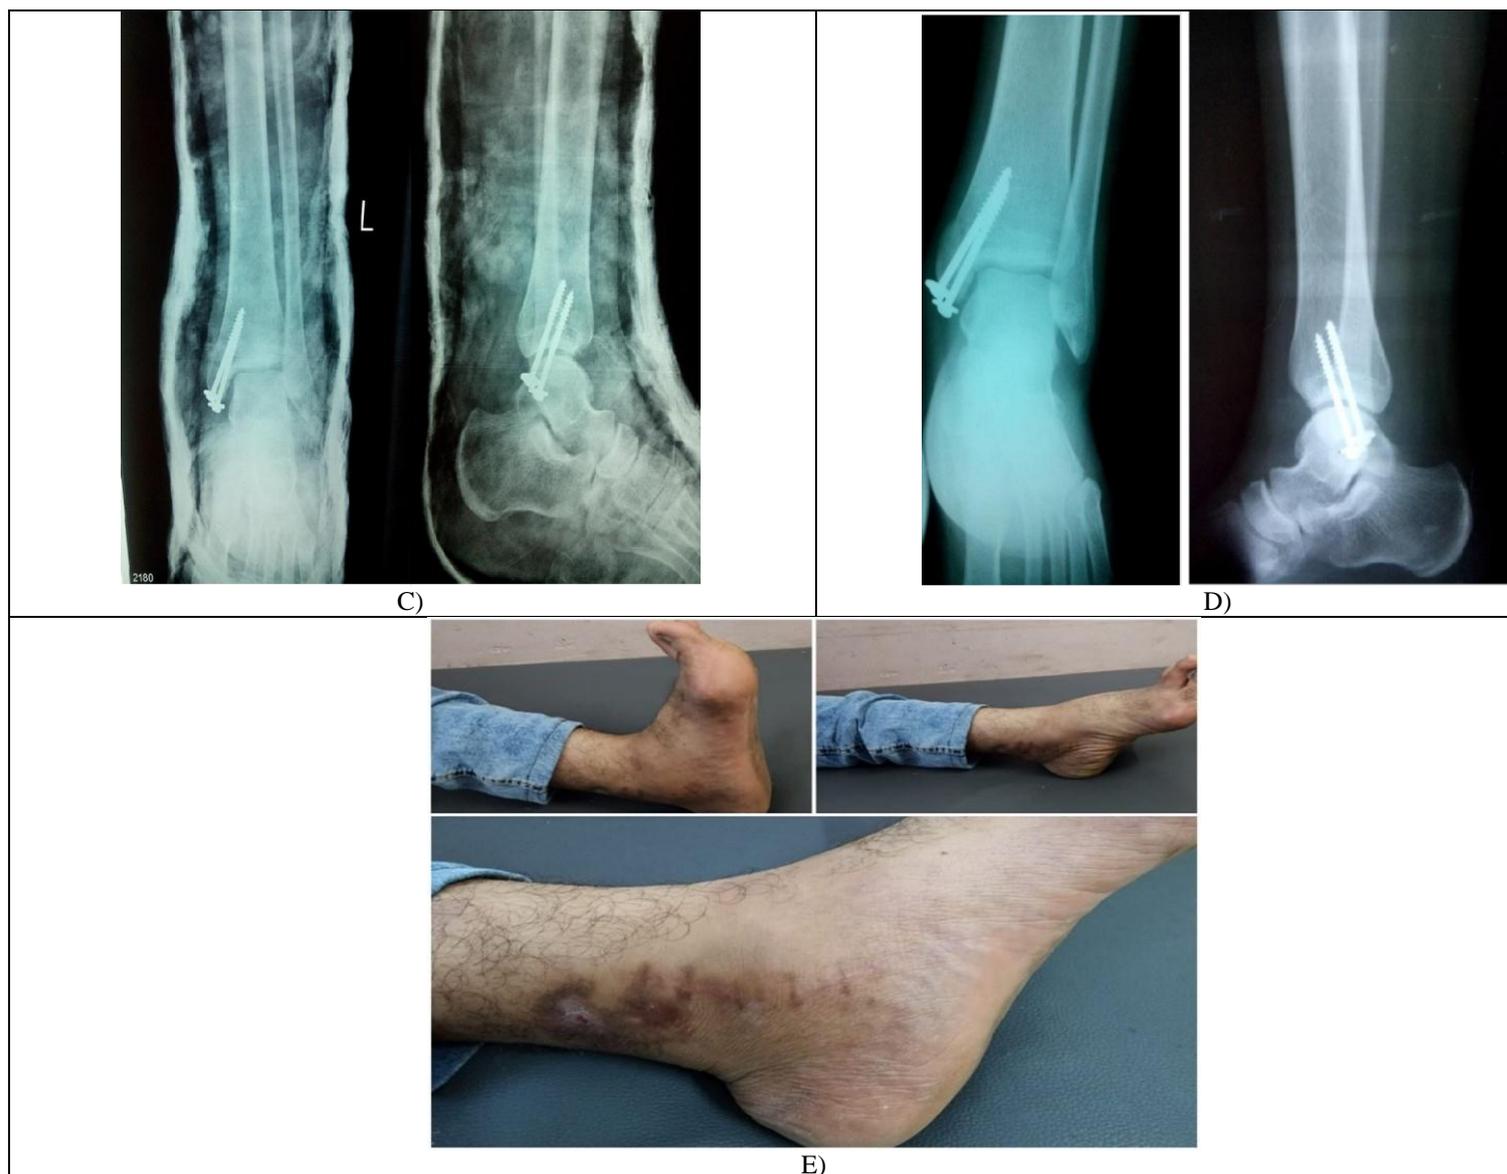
(A) The presenting X-ray of case 1, B) 6 weeks postoperative X-ray of case (1), C) month postoperative X-ray of case (1) and D) 6 month clinical outcome of case (1).
